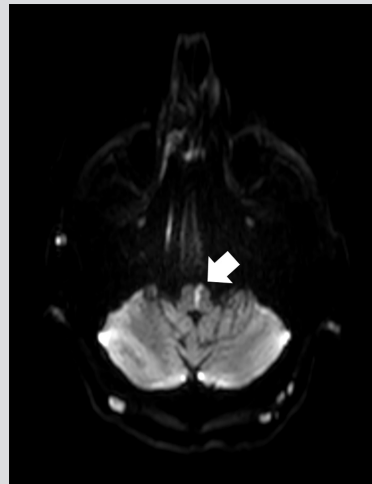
Diffusion weighted MRI image showing an infarct (white arrowhead) in the acute phase midline medulla and left pyramid
